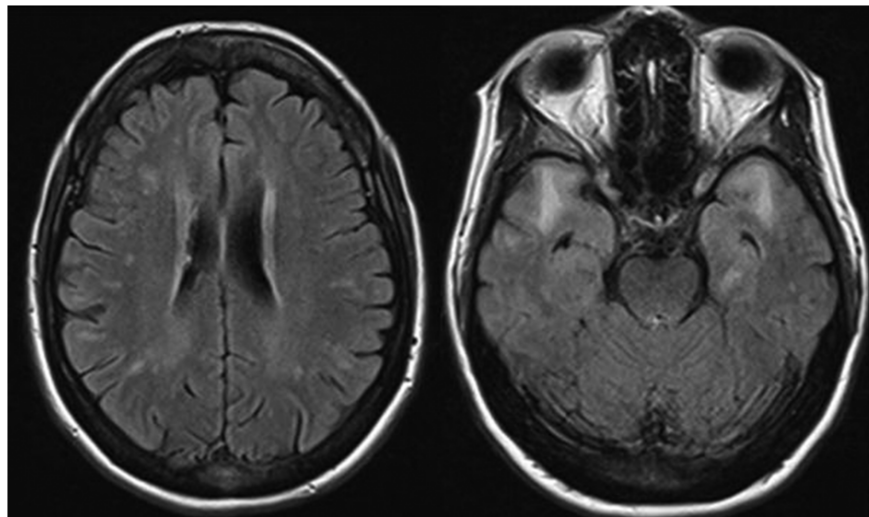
Axial T2 FLAIR images of a 49 year old woman with DM1, demonstrating hyperintense lesions in white matter, particularly affecting the anterior temporal lobes. Reproduced from Cabada *et al.* [161] with permission of Oxford University Press.
